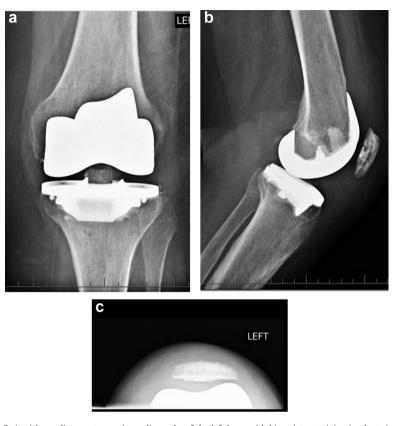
(a-c) Immediate postoperative radiographs of the left knee with bicruciate-retaining implants in place.
